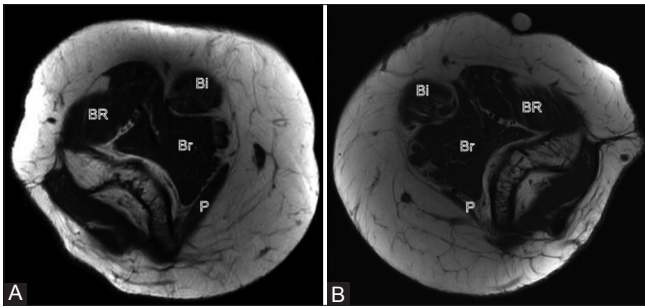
(A and B): Axial T1-weighted images of the left (A) and right (B) elbows show fatty atrophy of the pronator teres (P), brachialis (Br), brachioradialis (BR), and biceps (Bi) muscles, in keeping with chronic denervation change
